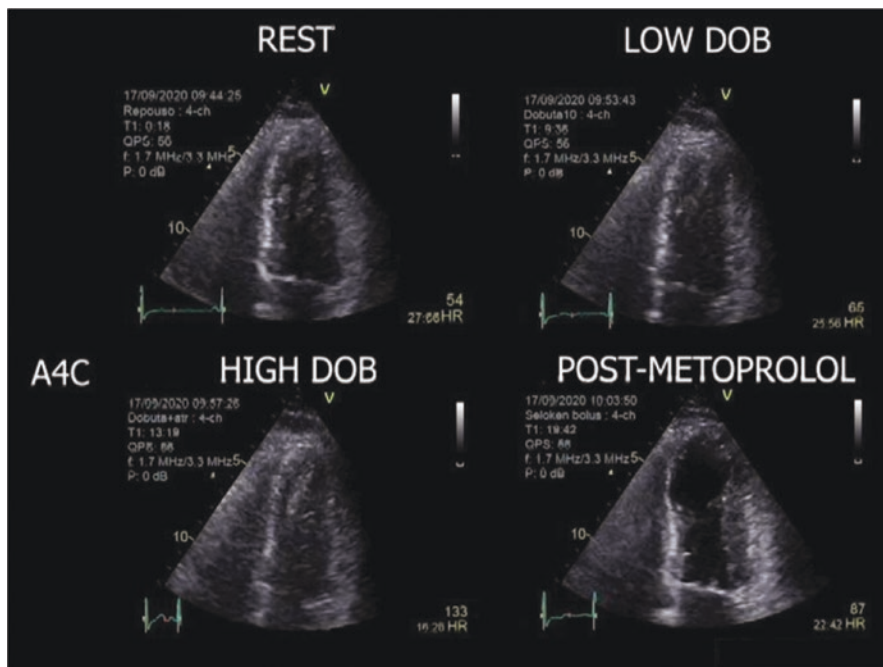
Apical four-chamber view showing end-systolic frames with normal wall thickening at rest (left upper panel), intermediate dose (right upper panel), and peak dose (left lower panel), with reduced thickening of the mid-septal, septoapical, apical, and middle lateral segments after metoprolol, in presence of left ventricular end-systolic cavity dilation. Apical four-chamber view (A4C) is shown at end-systole. See corresponding Video 18.4, inclusive of apical four-chamber, two-chamber, and three-chamber views. (By courtesy of Dr. José Luis Pretto, Passo Fundo, Brazil. The video is available under the chapter’s “Supplementary Material” on Springer Link)
